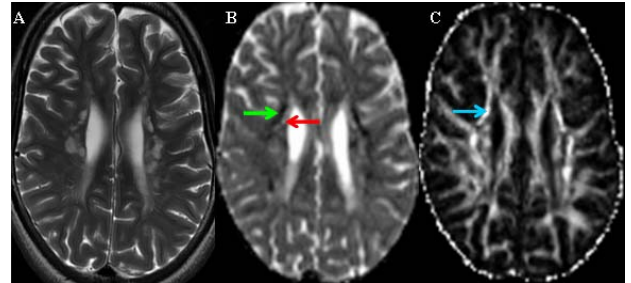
Axial images in a patient with LBSL. A) T2-weighted image showing white matter hyperintensity; B) MD map showing low (green arrow) and high (red arrow) MD values; C) FA map shows high FA values in the region with low MD (blue arrow).
